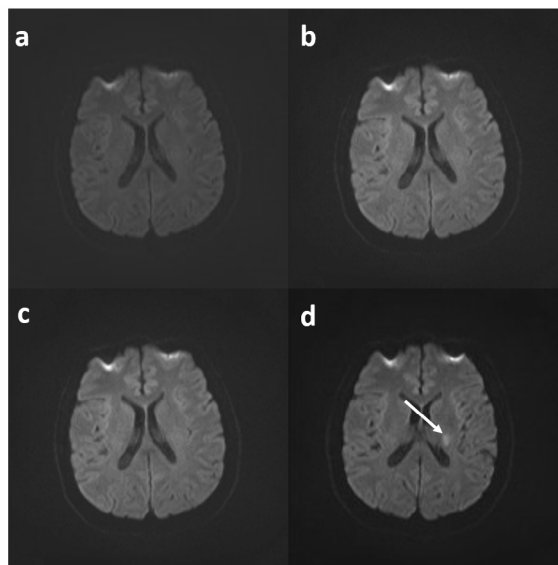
MRI layer Section 1: Acute stroke in the brain has been identified in a 44-year-old lady. Various b -values have been employed to improve the diagnosis of acute stroke: 0-1000 mm^2/s^2 (a) and 100-1000 mm^2/s^2 (b). 200-1000 mm^2/s^2 (c) and 300-1000 mm^2/s^2 (d). The findings indicate that b -values between 300 and 1000 mm^2/s^2 are better than other values.
